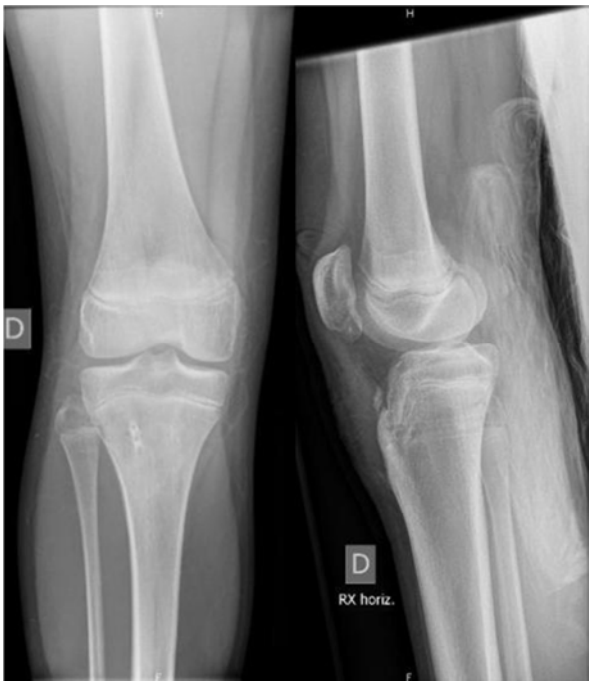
AP and lateral X-rays after the hardware removal showing consolidation of the fractures.
